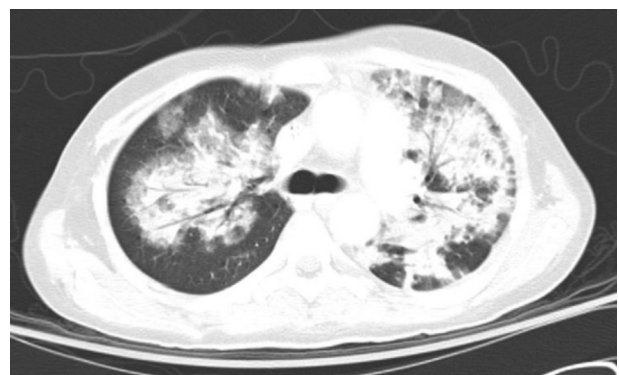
Chest CT image showing bilateral areas of consolidation in a patient with DAH. See Figure 1 legend for expansion of abbreviation.
